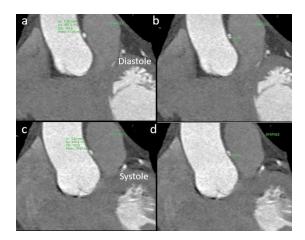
CT coronary angiography MPR image of 38 years old male with history of chest pain and positive TMT, showing systolic (c,d) (Area -5.5 mm^2 ; Diameter -1.6 mm) and diastolic (a,b) (Area -7.5 mm^2 ; Diameter -2.3 mm) phases of high interarterial course of RCA with significant change in caliber during cardiac cycle.
